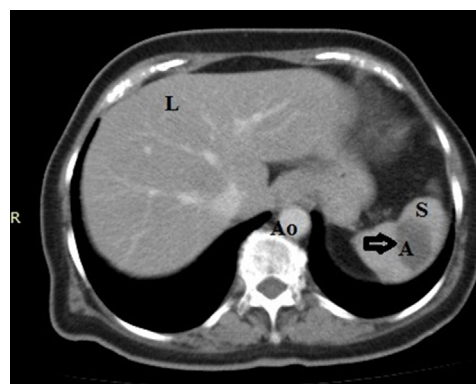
Transverse cut view of abdominal computed tomography showing abscess at spleen.
